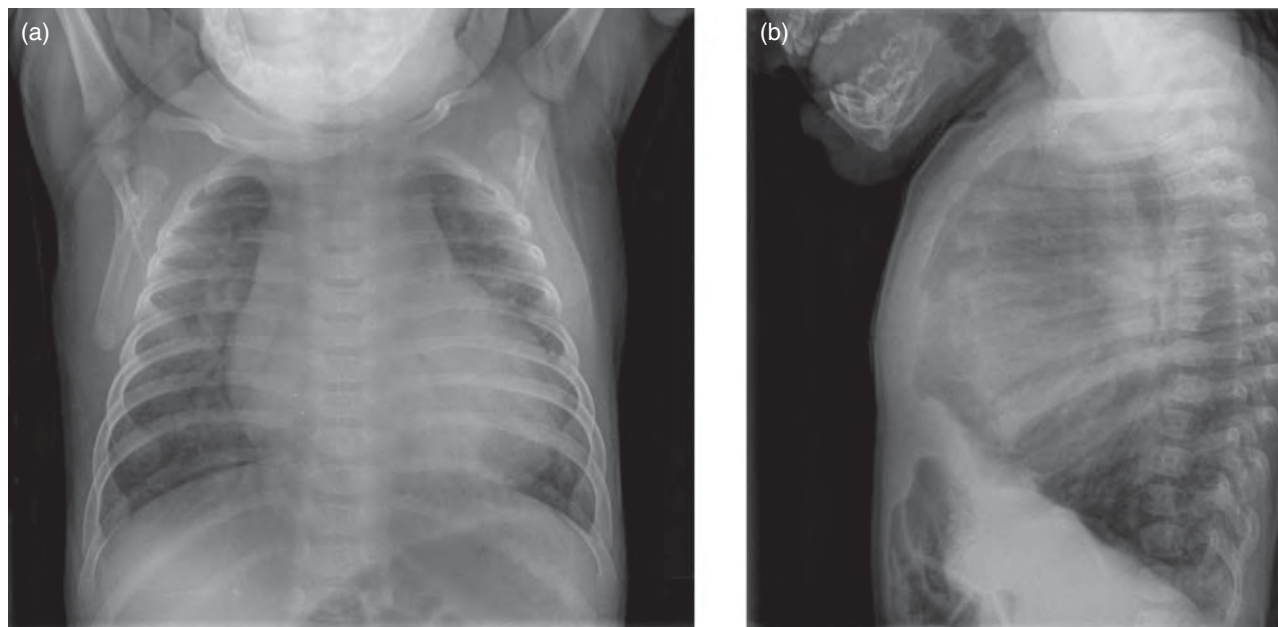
Chest X-ray of a patient with a large ventricular septal defect (VSD) in (a) anteroposterior and (b) lateral projections. Note the cardiomegaly with left atrial and left ventricular enlargement, increased pulmonary blood flow, and inferiorly directed cardiac apex.
